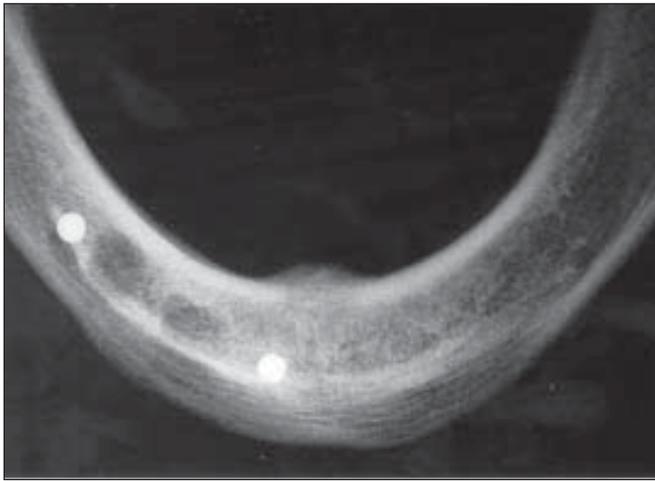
Occlusal radiograph taken with the surgical guide in place. Proposed implant site is identified using the radiopaque marker incorporated in the guide
